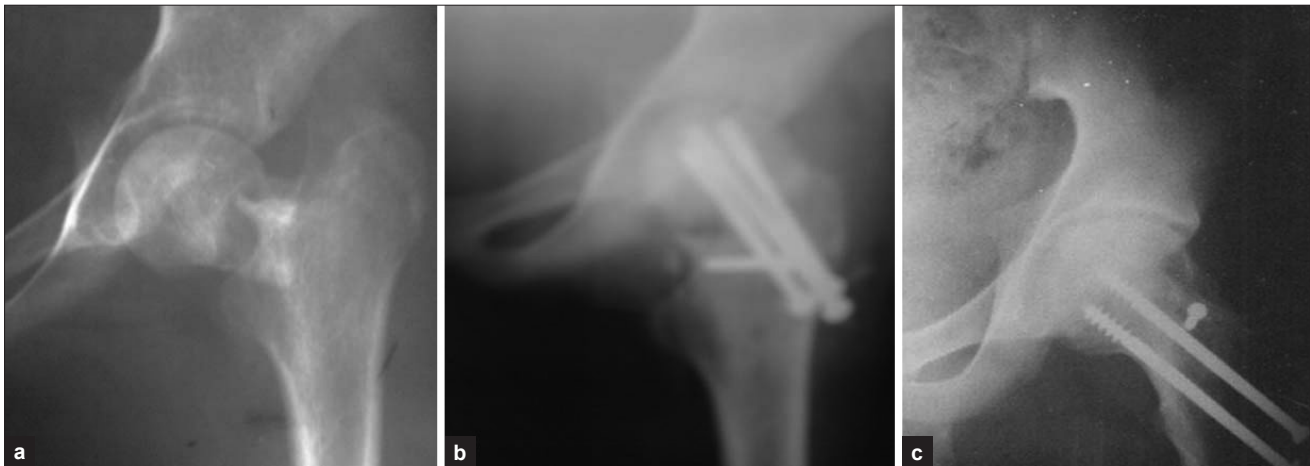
X-ray left hip joint anteroposterior view showing (a) 45 days old ununited femoral neck fracture (b) immediate postoperative X-ray (c) 2.6 years followup
